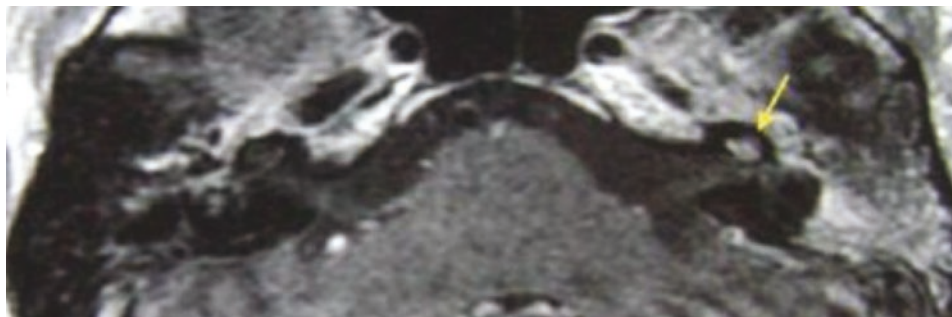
Magnetic resonance imaging of a 23-year-old female patient with acute otitis media (AOM) who presented with a severe hearing loss in the left ear and vertigo. In hear physical examination, otoscopy revealed the presence of intense erythema and bulging of the left ear.
